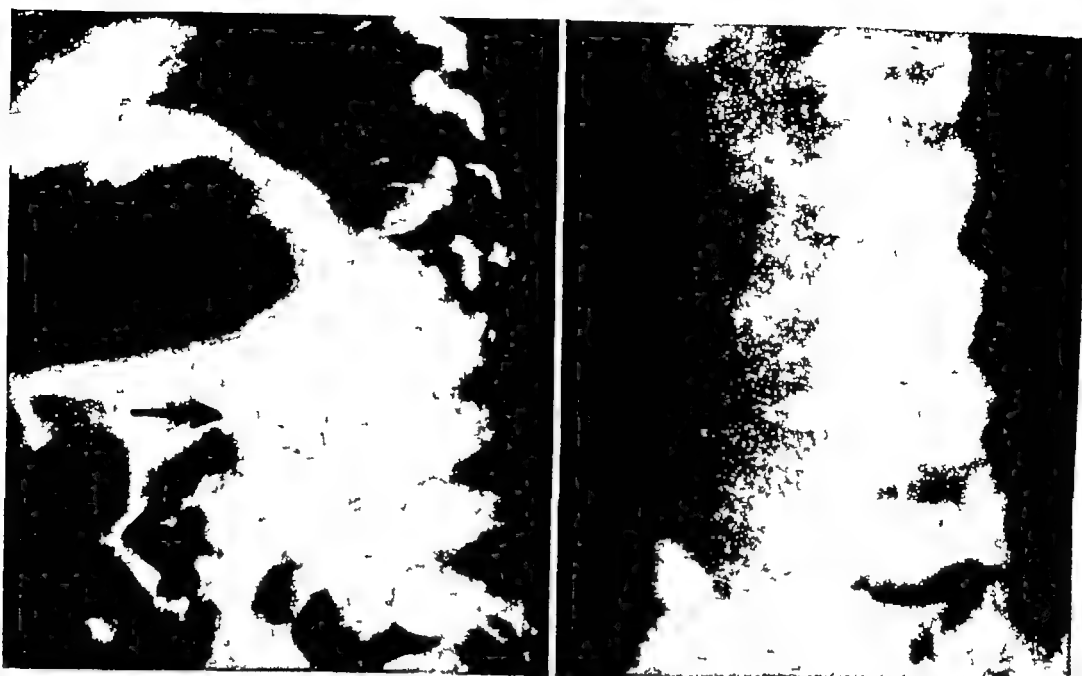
Neuroblastoma Roentgenograms demonstrating calcification in a large intraabdominal neuroblastoma (Pack, Horning, and Ariel, *J Neuropath & Exper. Neurol* 11 235, 1952)
